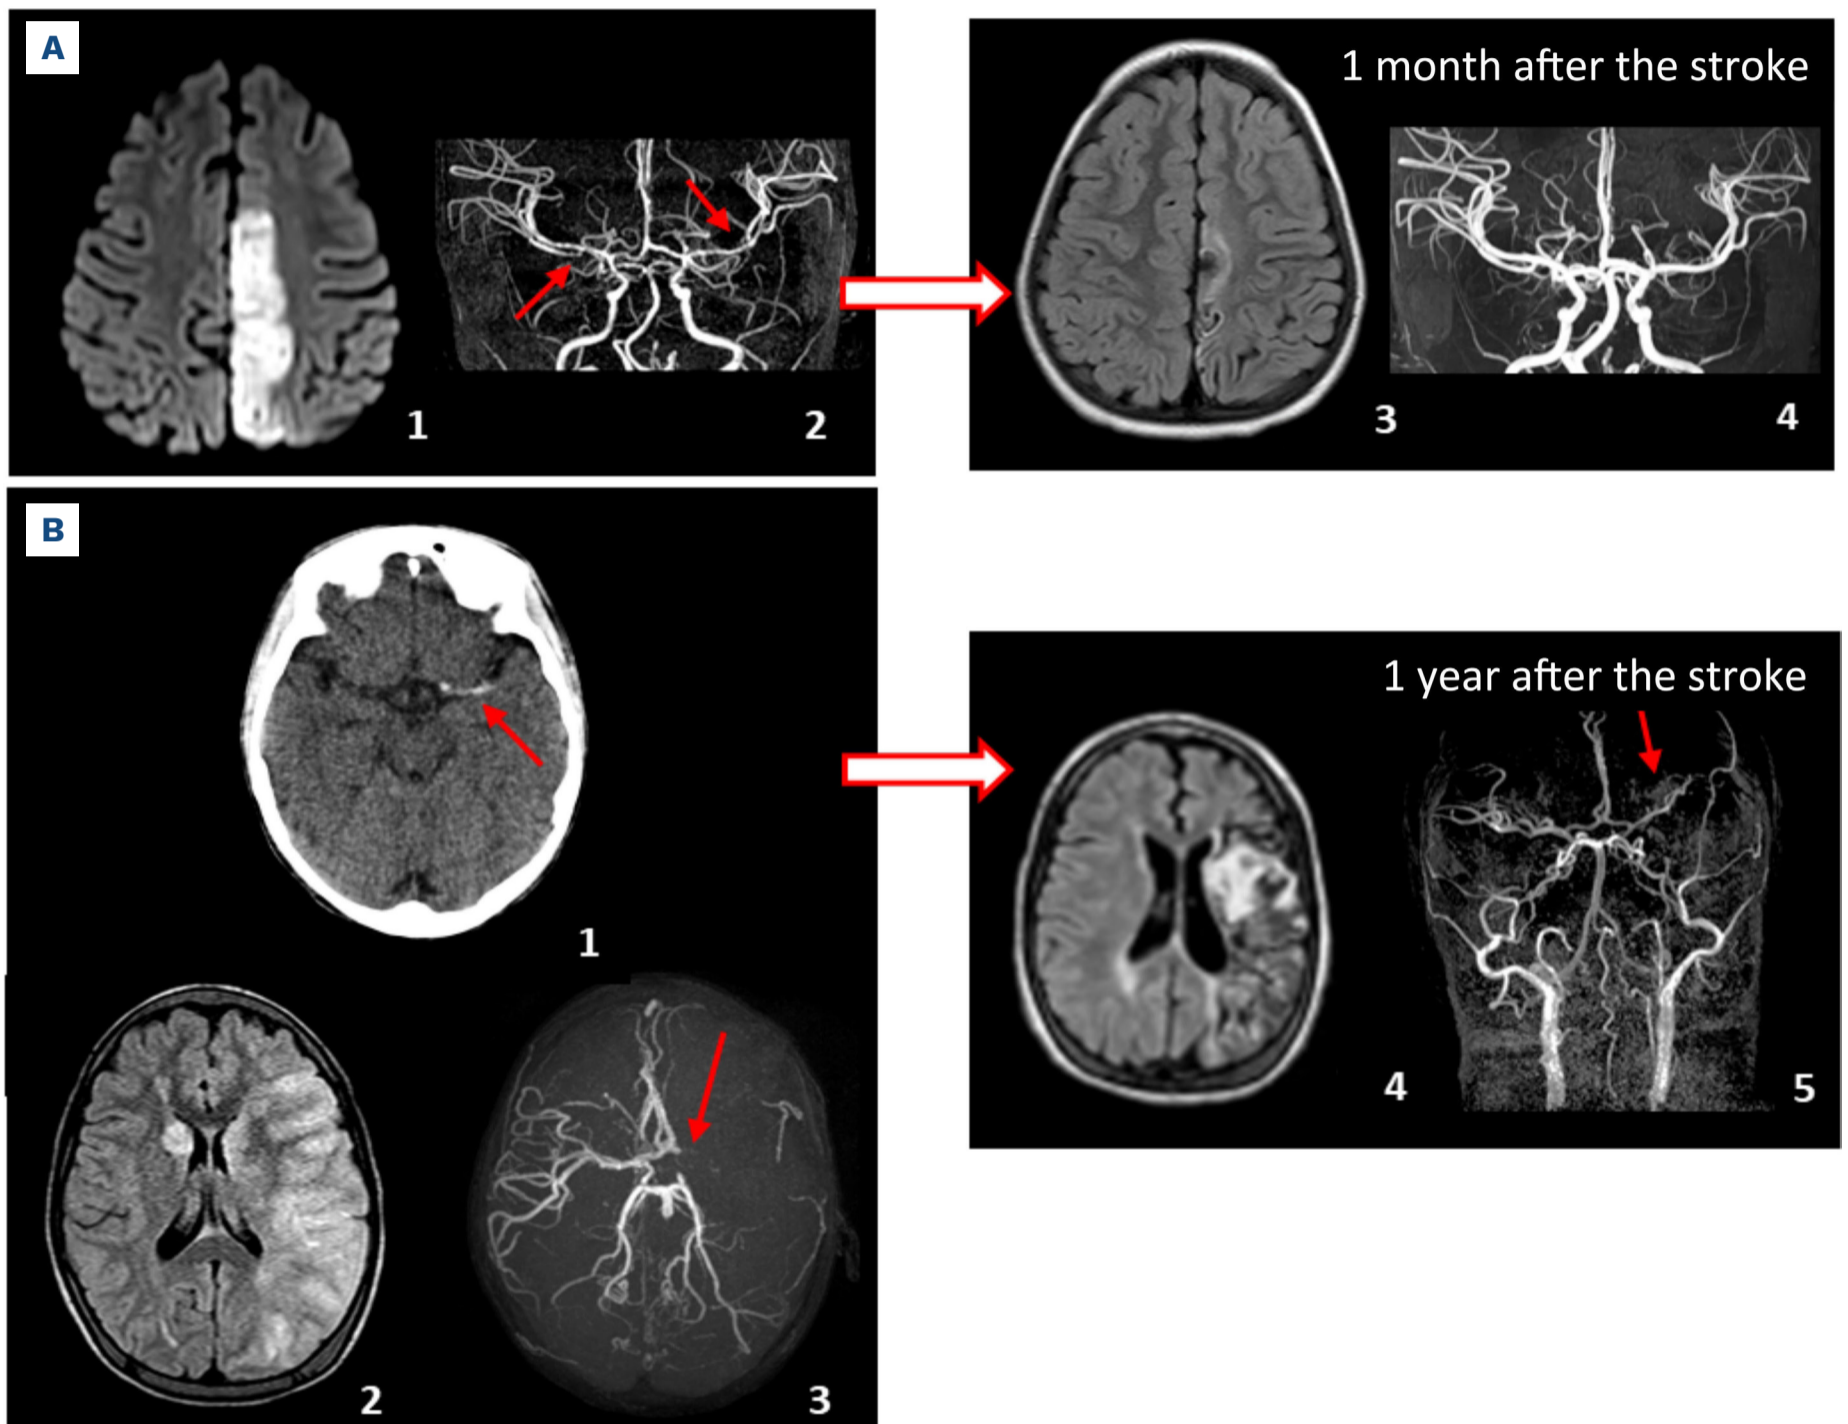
Course of ischemic stroke and vascular aspect on representative magnetic resonance images and magnetic resonance angiography in patients with no sickle-related arteriopathy.
